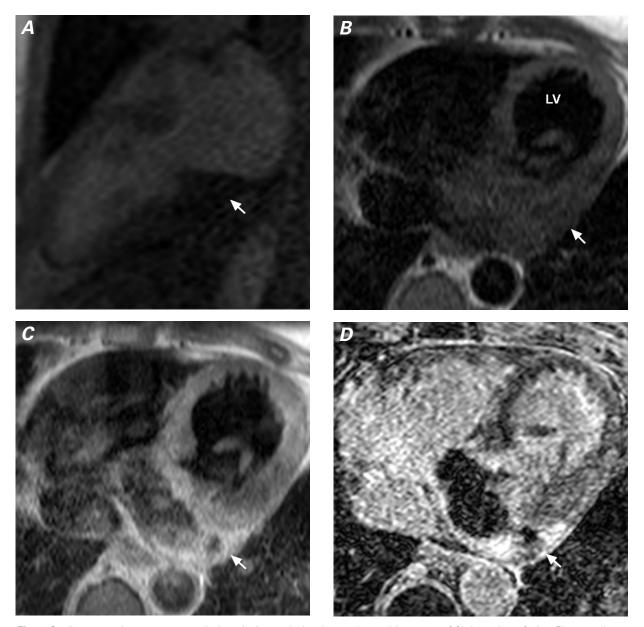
Cardiac magnetic resonance reveals the mitral paravalvular abscess (arrows) by means of A) dynamic perfusion, B) pre- and C) post-contrast T1-weighted double-inversion recovery, and D) delayed enhancement modes.
